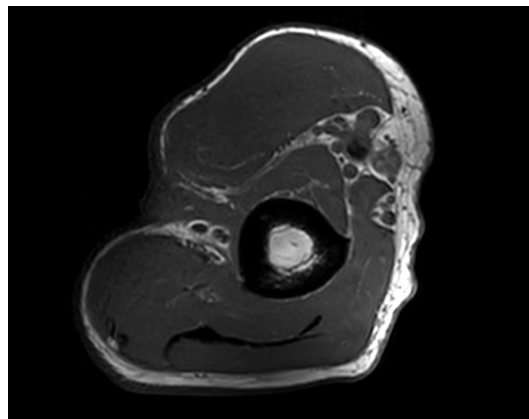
MRI after 7 months after FTSG
